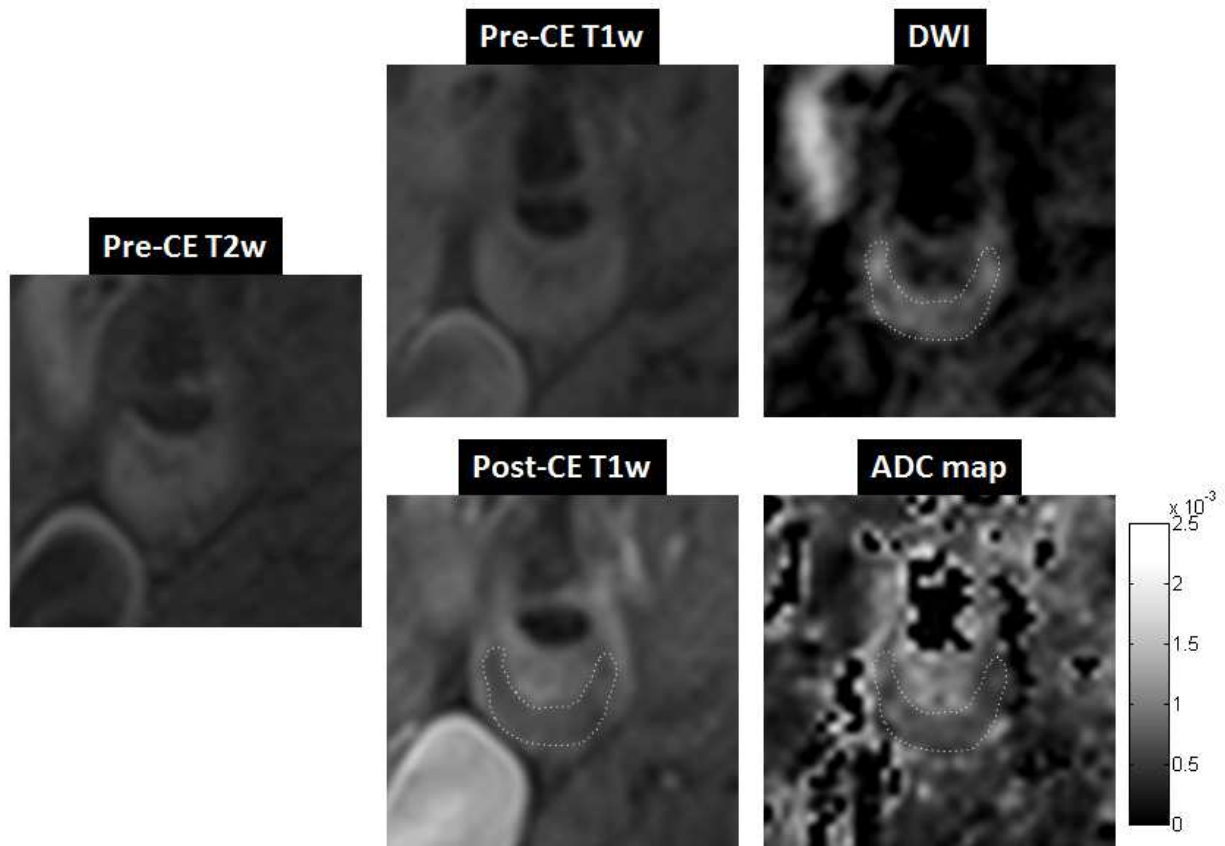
A case study of a symptomatic subject with an atherosclerotic plaque of 70% stenosis in the right internal carotid artery. Pre-contrast T2-weighted image showed slightly hyper-intense signal throughout the plaque area. Pre-contrast T1-weighted image was iso-intense in the plaque area. Post-contrast T1-weighted image showed a clear hypo-intense area within the plaque, a typical LRNC appearance, surrounded by enhanced fibrous plaque tissue. DWI ($b = 300$ mm²/s) using DP-TSE showed a hyper-intense region, i.e. low diffusion, that spatially matched to the LRNC area in the post-contrast T1-weighted image. ADC map showed an area with low diffusion ($0.62 \pm 0.15 \times 10^{-3}$ mm²/s) within the plaque that spatially matched to the LRNC finding in the post-contrast T1-weighted image.
